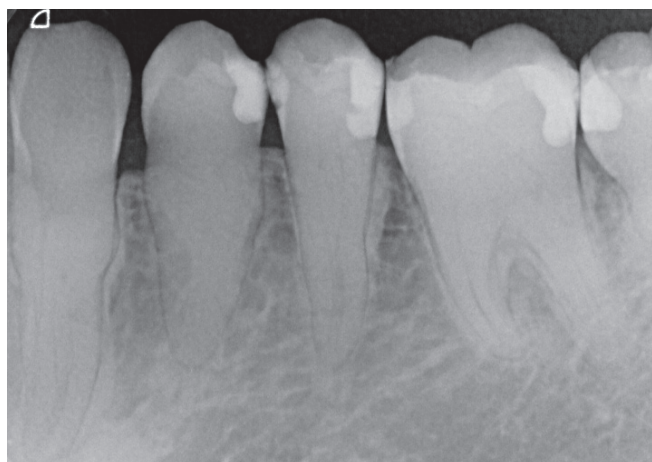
Periapical radiographs showing irregular areas on the root surfaces and enlargement of the coronal third of the roots
